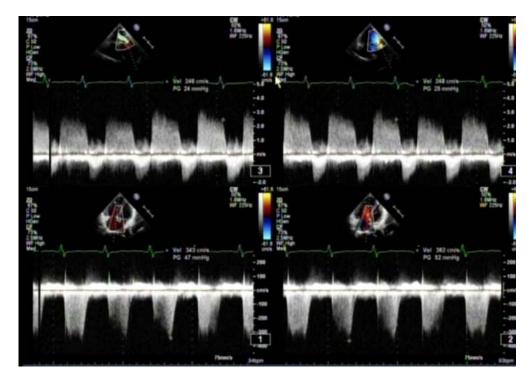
Echo shows continuous wave Doppler across the tricuspid valve indicating moderate PHT/ continuous wave Doppler across the pulmonary valve indicating moderate pulmonary regurgitation due to PHT
